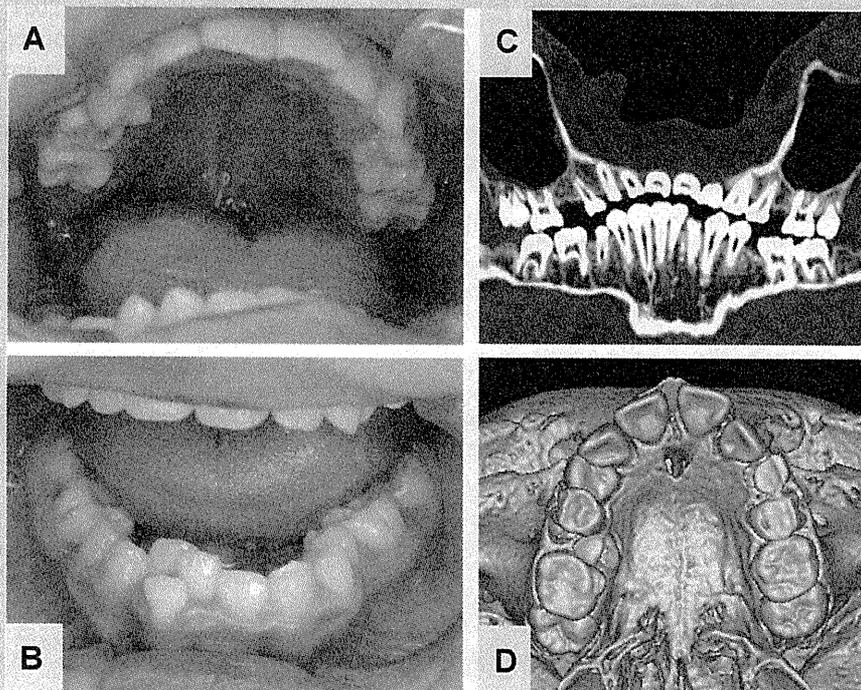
Oral photographs (A,B) and MDCT-synthesized panoramic radiograph (C) of Patient 7 at age of 10 years and MDCT-synthesized upper dental arch of Patient 6 at age of 7 years (D). Note: high palate, malocclusion, small dental arch, excessive tooth wear (A,B), missing upper second premolars on both side and lower left second premolar (C), ectopic tooth eruption of first molars on both side (D).
